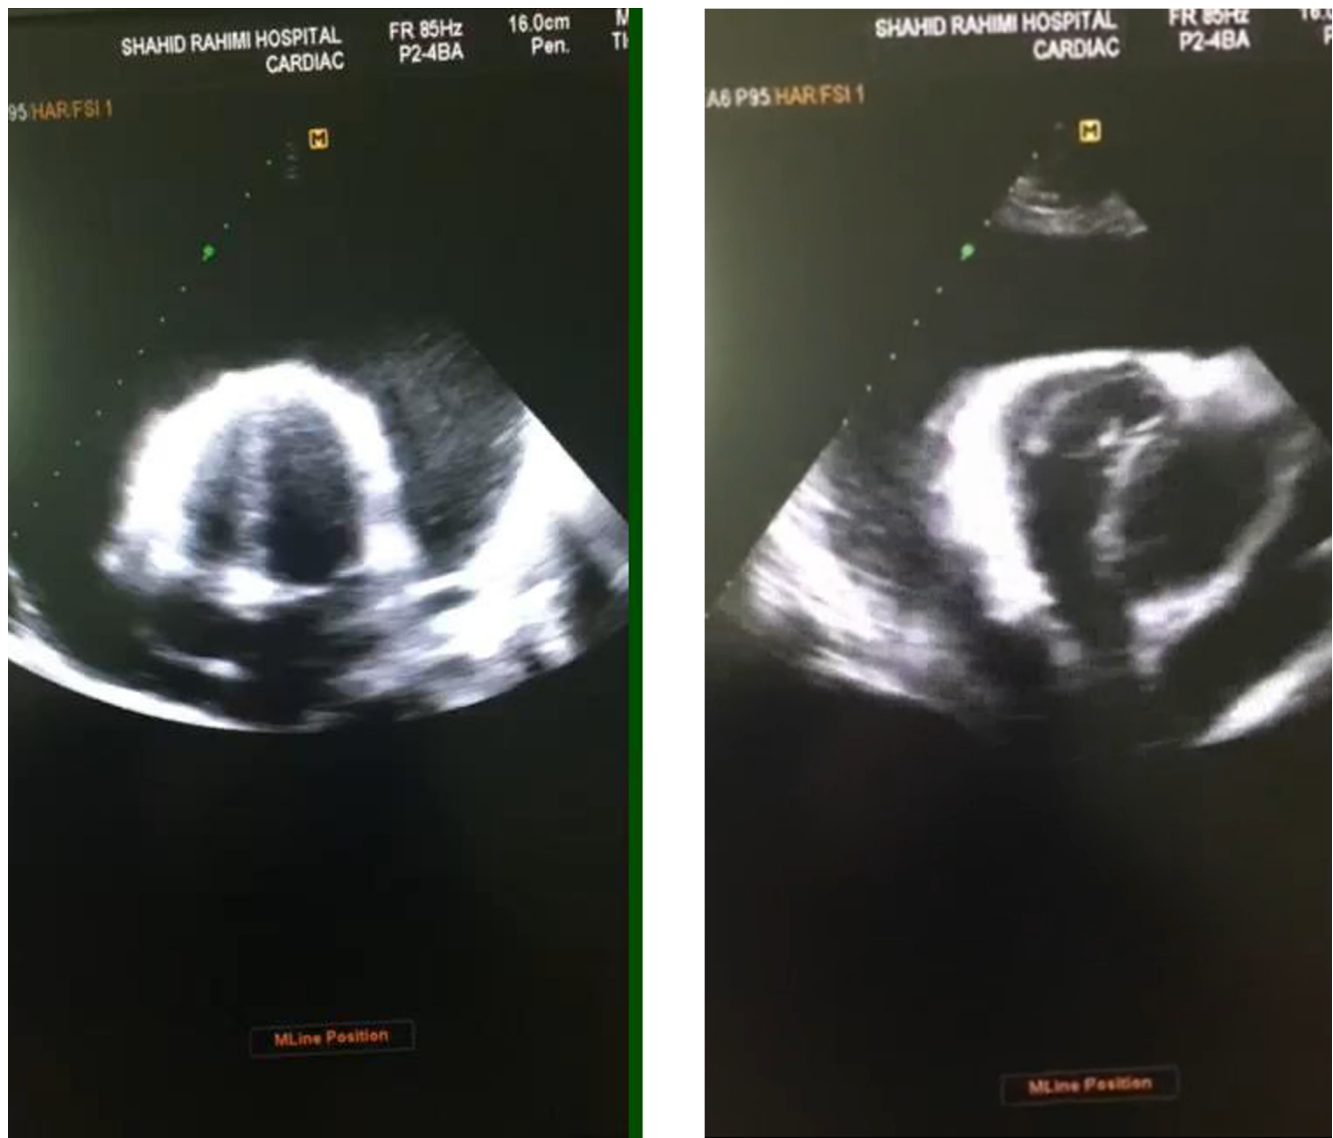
Transthoracic echocardiography at the time of admission, showing good left ventricular ejection fraction (65%) and a large pericardial effusion (3.6 cm) and a complete collapse of the right ventricle.
